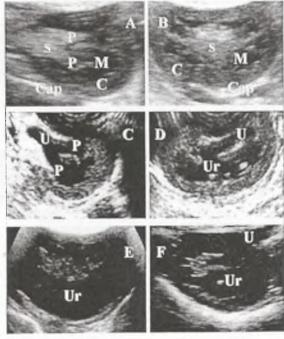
Ultrasonography examination of normal kidney (Transverse section (A) & Sagittal section (B)), mild hydronephrotic kidney (Transverse section (C) & Sagittal section (D)) and sever advanced hydronephrotic kidney (Transverse section (E) & Sagittal section (F)). S= renal sinus, P = renal pelvis, M =renal medulla, C = renal cortex, Cap = renal capsule, U = ureter & Ur = urine.
